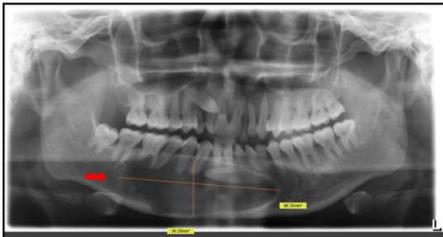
PANORAMIC RADIOGRAPH SHOWS UNILOCLAR RADIOLUCENCY IN LOWER BODY OF MANDIBLE
